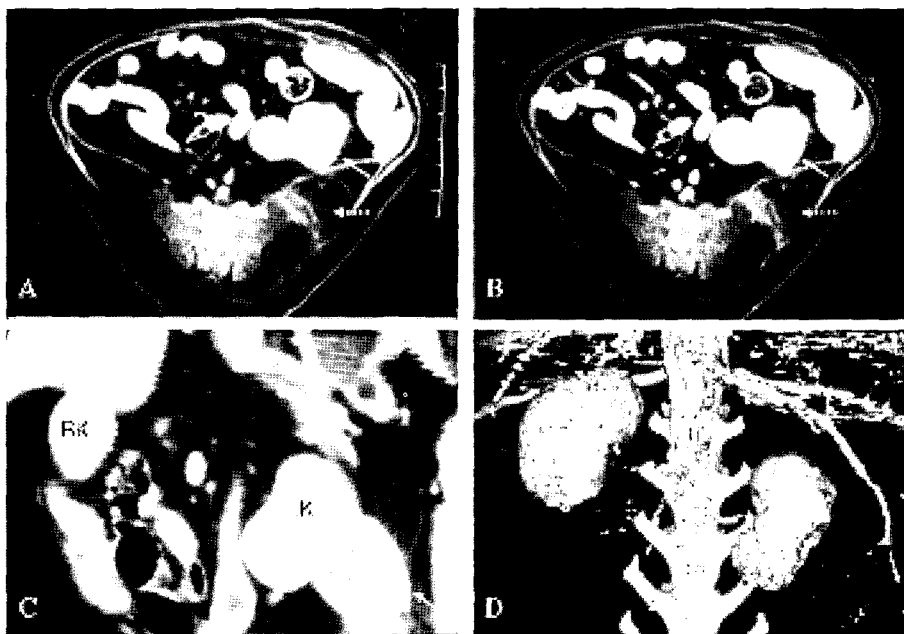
Pre-contrast (A) and post-contrast (B) transverse CT images at the level of the 3th lumbar vertebra in case 2. Note the hyperdense pararenal mass with a thick peripheral rim that showed a marked rim enhancement after contrast agent infusion (arrow). No gas or calcification was shown. Hyperdense lesion was seen at the left rump muscle (dotted arrow). The sagittal reformatted CT images, the invasion or pressure of the abdominal mass to left kidney is identified (C). Reformatted 3-D image of kidney revealed pressure of caudal portion in the left kidney (D).
